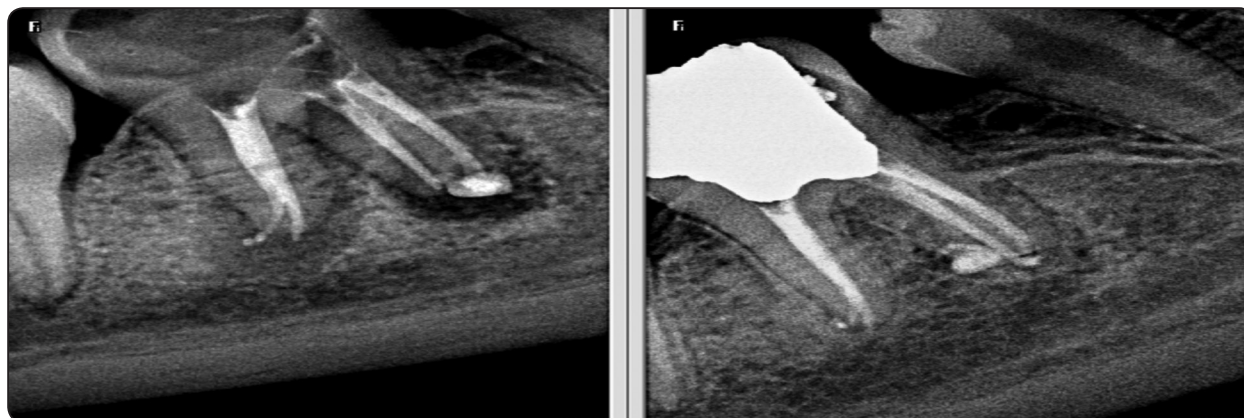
Radiographic signs of good apical and periradicular healing when combined with clinically asymptomatic tooth denote successful root canal treatment.
